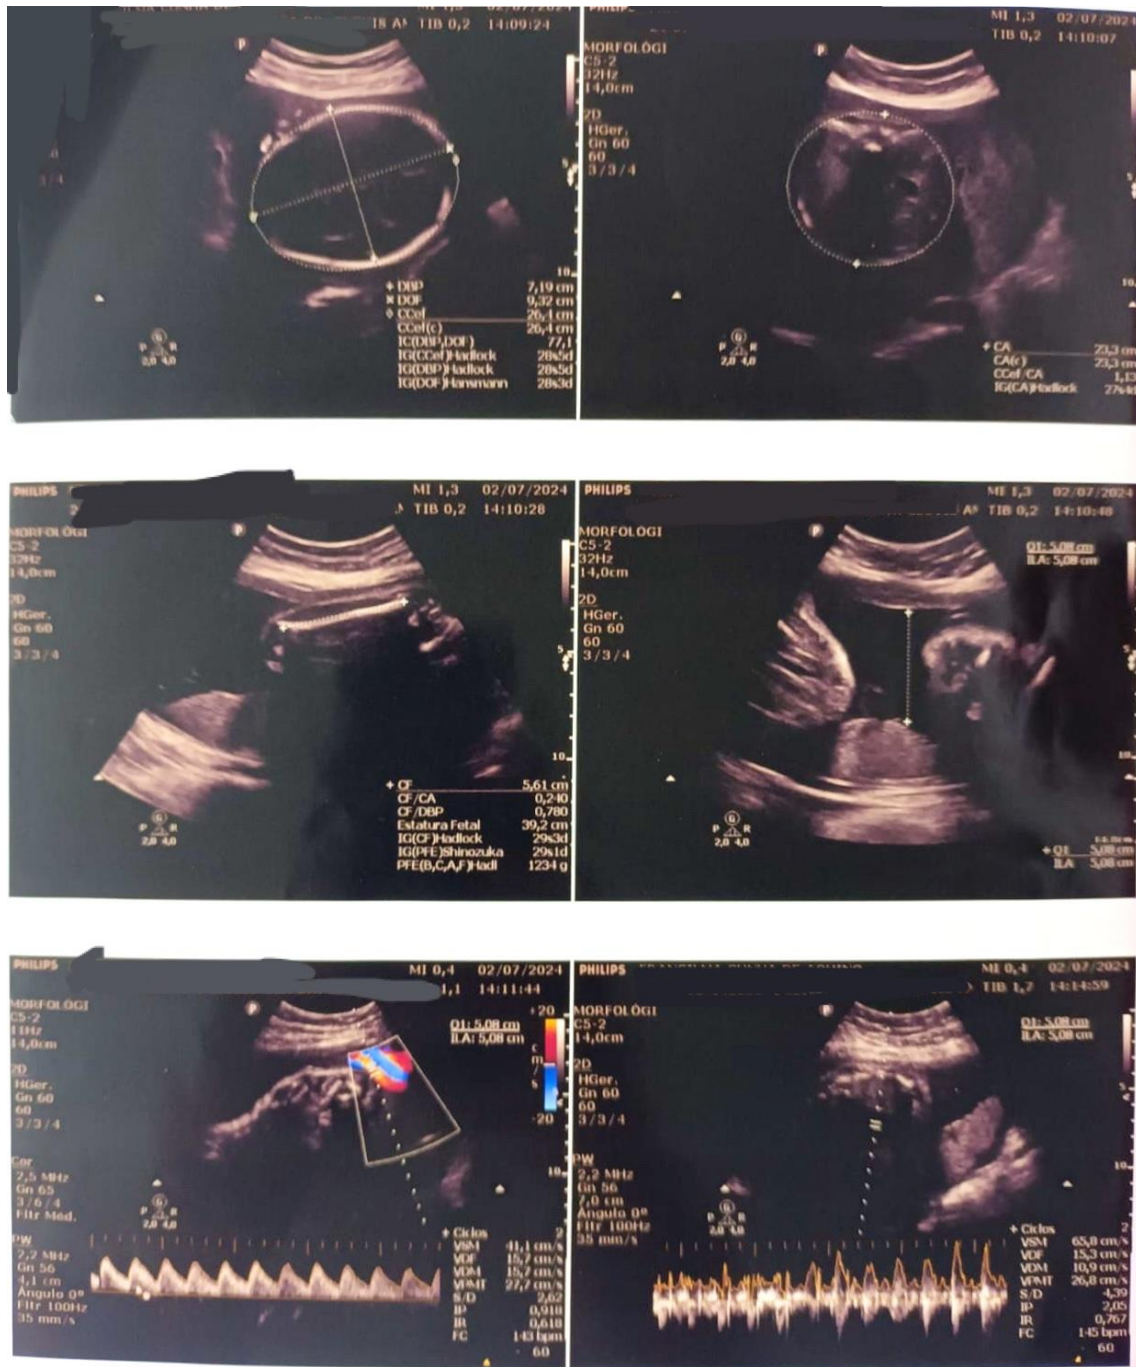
Ultrasound image taken on July 5, 2024, showing fetal biometric measurements at 31 weeks and 1 day of gestation. The scan shows any notable feature, with no abnormalities detected in fetal or placental morphology at this stage.
